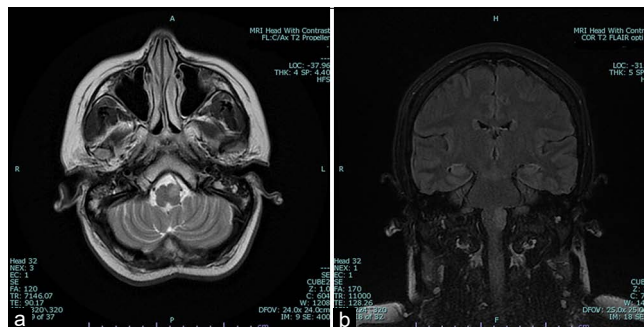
(a) Axial T2-weighted magnetic resonance image showing signal increase in the anterior medulla oblongata (more pronounced on the left) consistent with hypertrophic olivary degeneration. (b) Coronal T2 FLAIR magnetic resonance image showing hyperintensity over the region of the inferior olivary nucleus.
